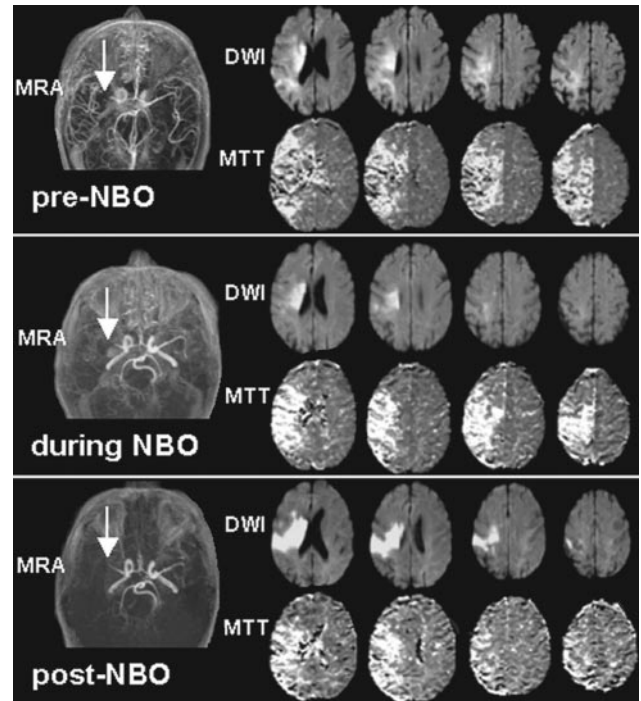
Serial MRI findings in a patient with cardio-embolic right MCA stroke treated with NBO for 8 hours. Top, Baseline (pre-NBO) MRI, 13.1 hours after symptom onset, shows a large DWI lesion, a larger MTT lesion, and MCA occlusion (arrow) on head MRA. Middle, A second MRI after 3.75 hours (during NBO) shows 36% reduction in the DWI lesion, stable MTT deficit, and persistent MCA occlusion. Bottom, A third MRI after 24 hours (post-NBO) shows reappearance of DWI abnormality in some areas of previous reversal; MTT image shows partial reperfusion (39% MTT volume reduction, mainly in the ACA territory); MRA shows partial MCA recanalization.
